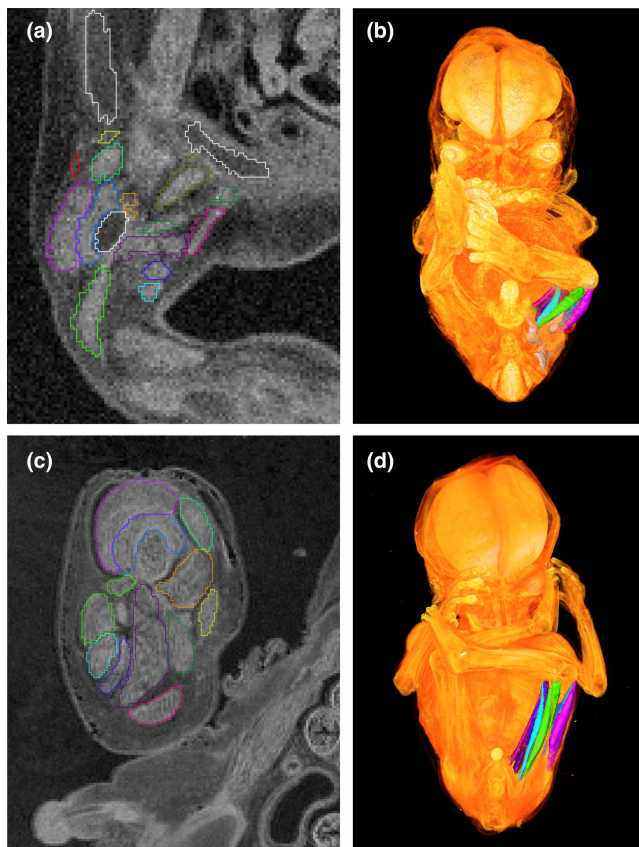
Segmentation of musculoskeletal system components. (a, c): A 7 T magnetic resonance image of an early fetus. (b, d): Musculoskeletal system model reconstructed using Amira software. (a, b): CRL 21.3 mm (8-week GA). (c, d): CRL 43 mm (13-week GA). The color codes are the same as in [Figure 3](#).
